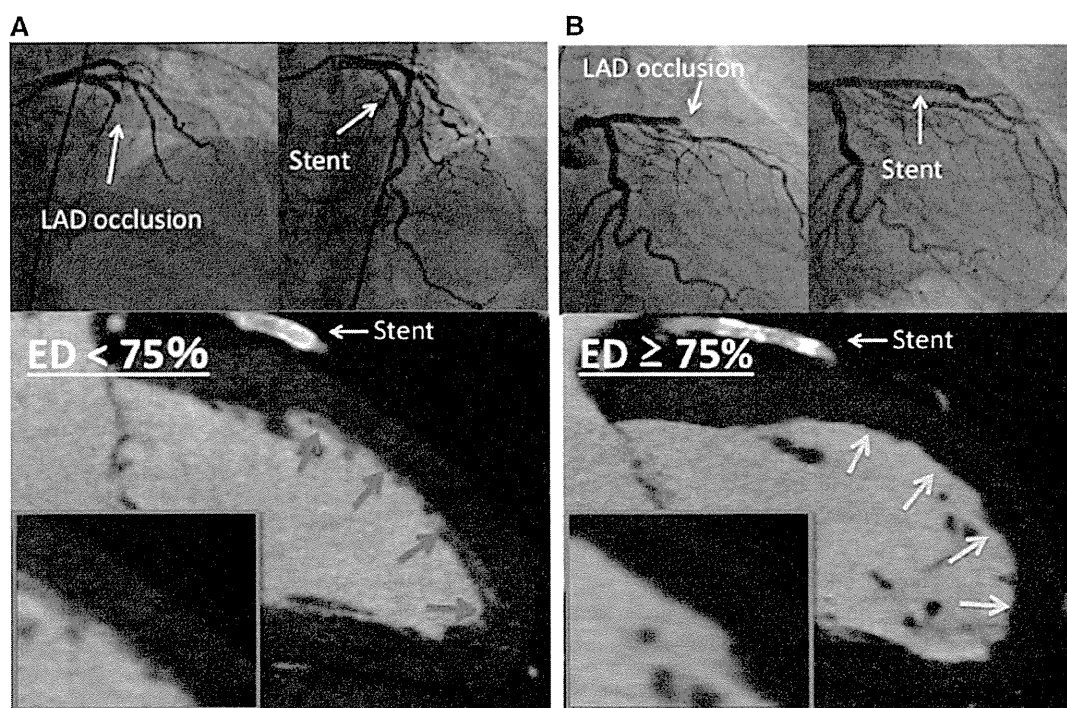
ImageXact<sup>®</sup> software (Toshiba Medical Systems) was used to select a single cardiac phase with minimal motion artifacts at mid-diastole or end-systole for reconstruction using a standard convolution kernel. We assessed the ED extent in longitudinal or 4-chamber views on multiplanar reconstruction images with a slice thickness of 3 mm, CT window width of 450–550, and a window level of 150–250 HU.
